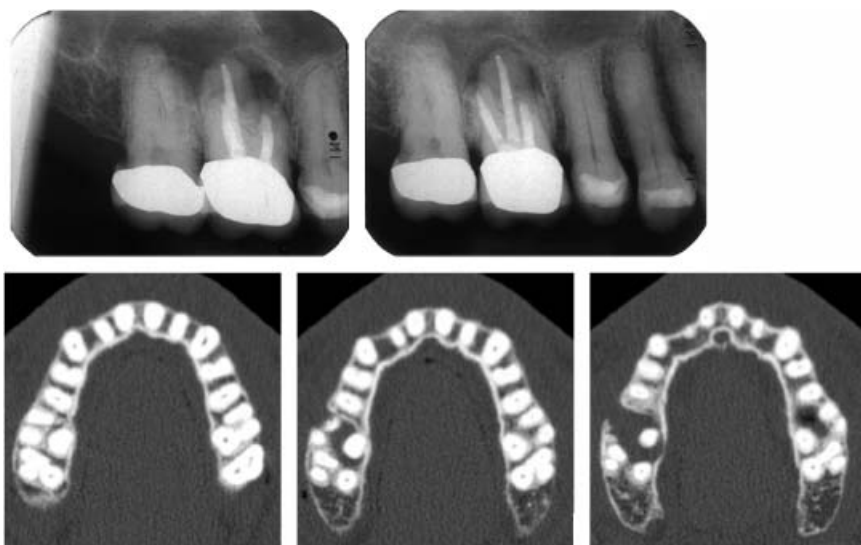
Some of the axial slices obtained at computed tomography, using a low-dose technique, to evaluate the conditions around the apices of the upper right first molar, before endodontic surgery. Not only can lesions now be clearly seen at all root apices. The relation between the roots and the location of their apices relative to the buccal and palatal bone plates can be accurately assessed.
